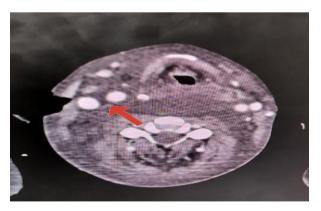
Axial section of contrast enhanced CT of neck showing fluid collection involving retropharyngeal and parapharyngeal space with extension to anterior cervical space causing separation of right internal jugular vein and carotid artery.
